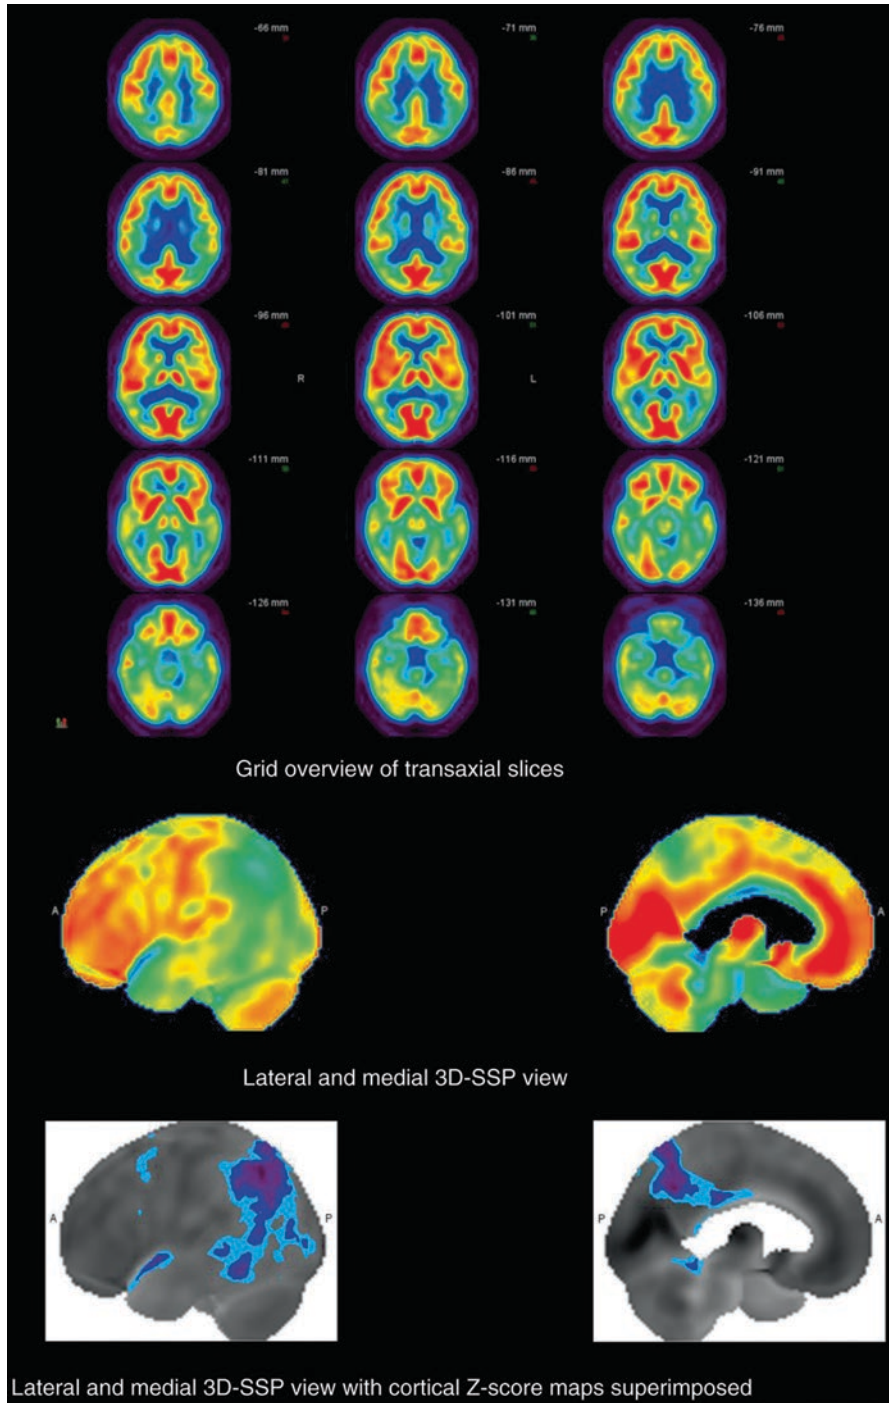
[^{18}F]FDG brain PET data of a patient suffering from Alzheimer's disease (AD)
